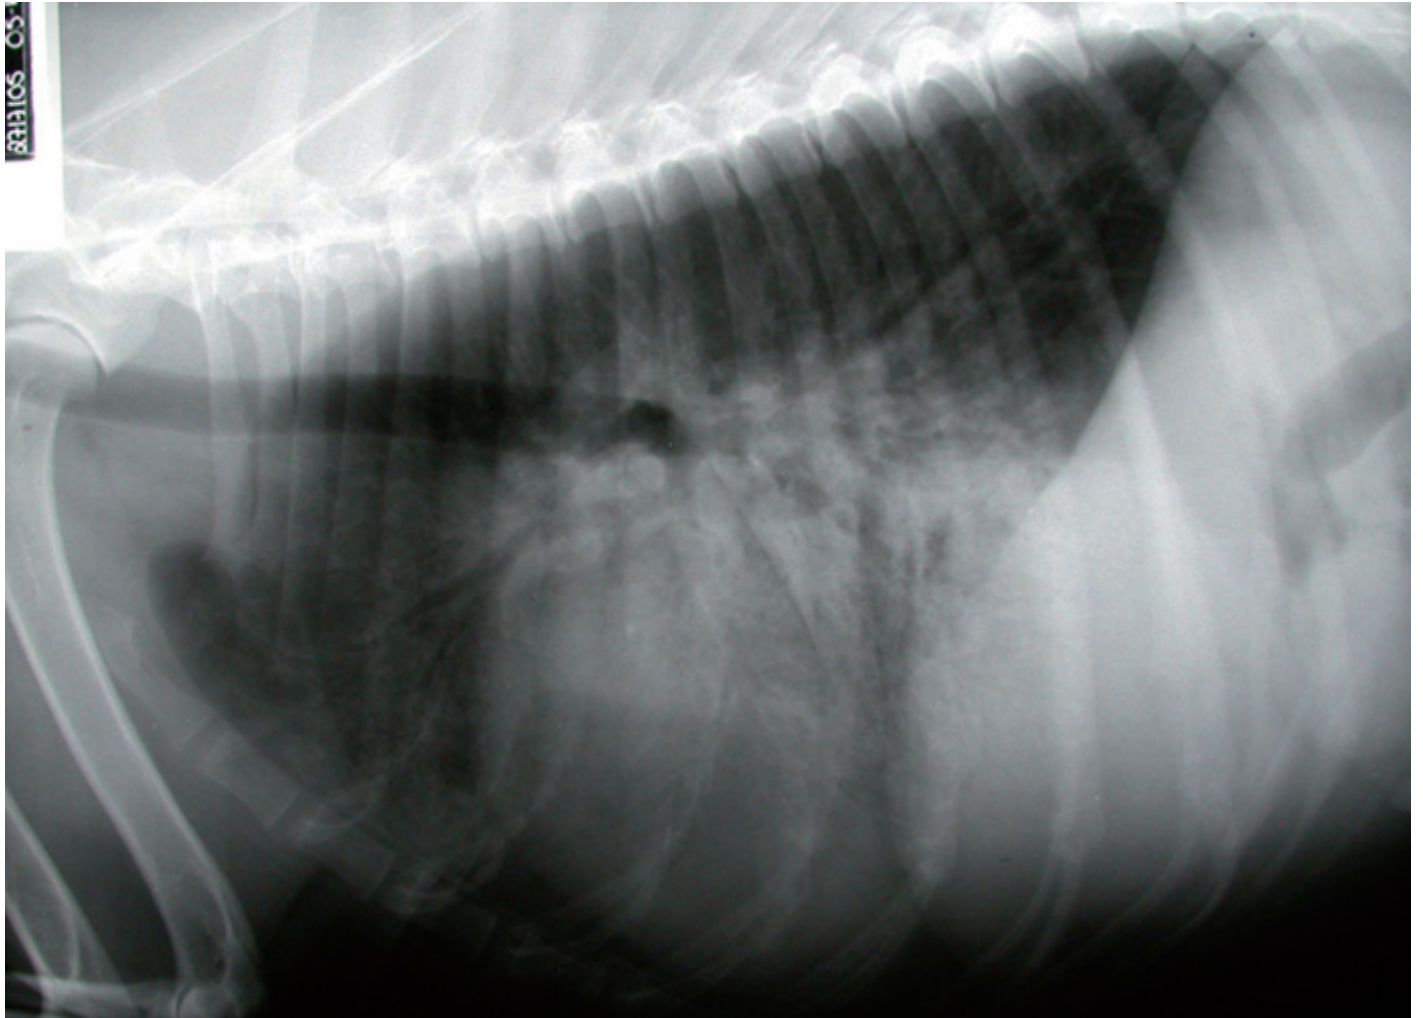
(left). Right lateral thoracic radiograph of a Doberman with DCM in acute congestive failure showing perihilar and cranioventral pulmonary oedema, with air bronchograms.
